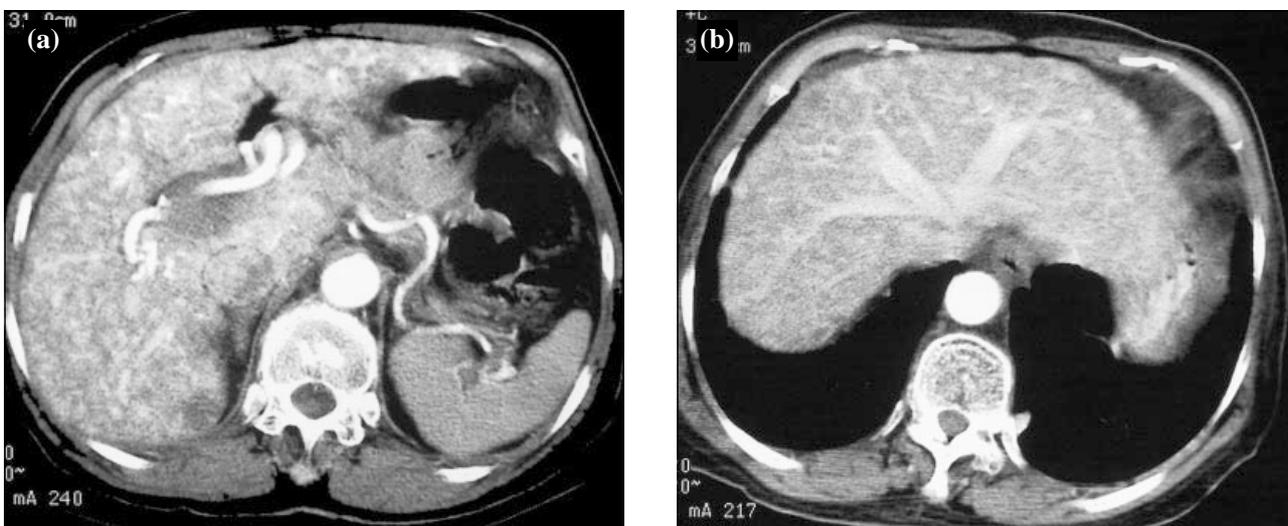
Arterial phase of contrast enhanced computed tomography images. (a) The dilated hepatic artery demonstrating heterogeneous enhancement of the hepatic parenchyma, suggesting diffuse telangiectasis; (b) early filling of the hepatic veins, indicating the presence of an arteriovenous shunt.
